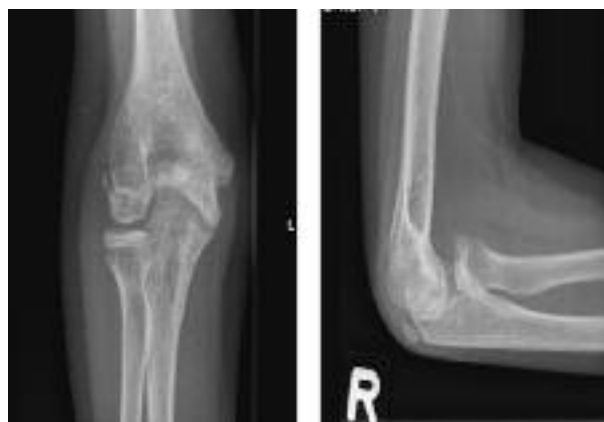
Radiograph of the distal humerus with fishtail deformity of the girl 8 years after trauma.
